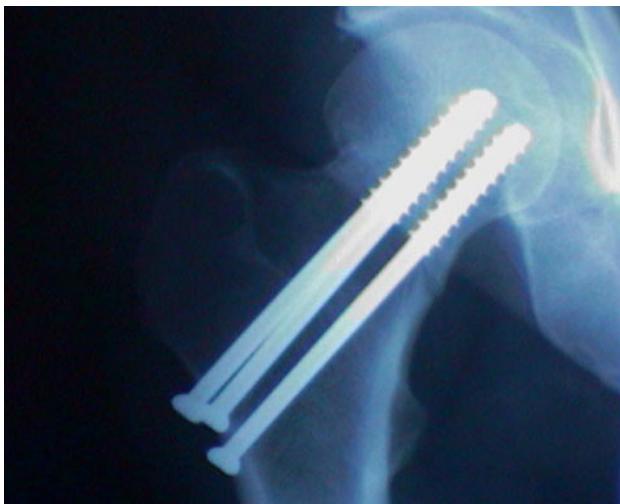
Management of a subcapital fractured neck of femur with three cannulated screws, antero-posterior radiograph
